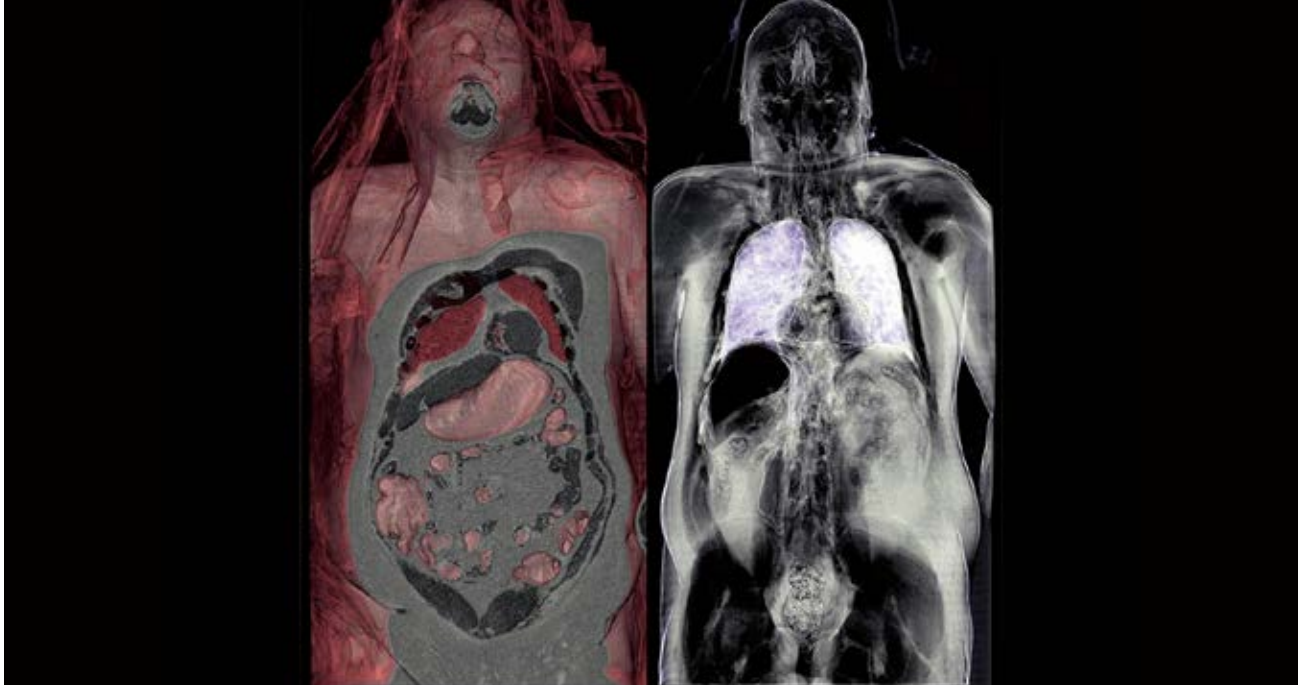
Postmortem Dual Energy computed tomography angiography. The captured data rendered with two different translucencies settings so that soft tissue and air in the body can be visualized by volume rendering 3D.
